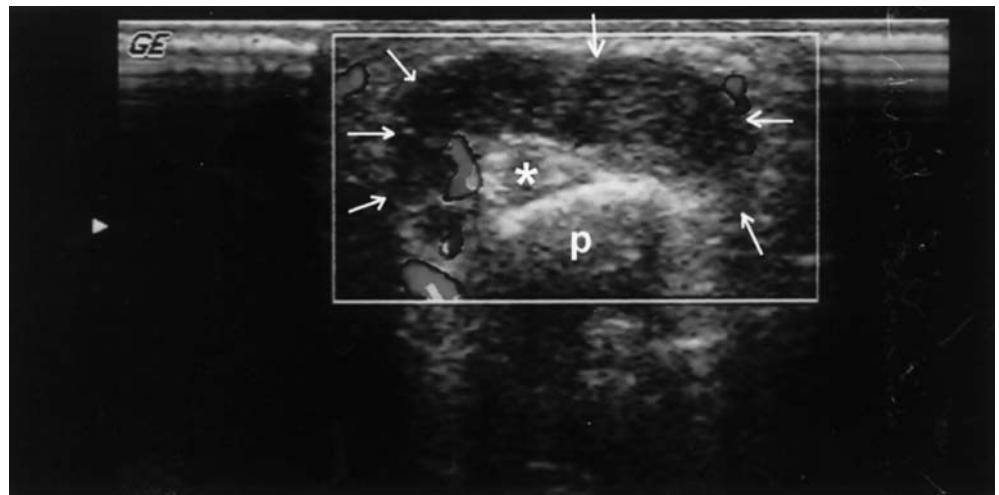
Homogeneous giant cell tumor (*small arrows*) in axial echo Doppler which displaces the palmar neurovascular bundle without invasion. Ultrasound was enough to make the diagnosis. *Asterisk* tendon; *p* phalanx
